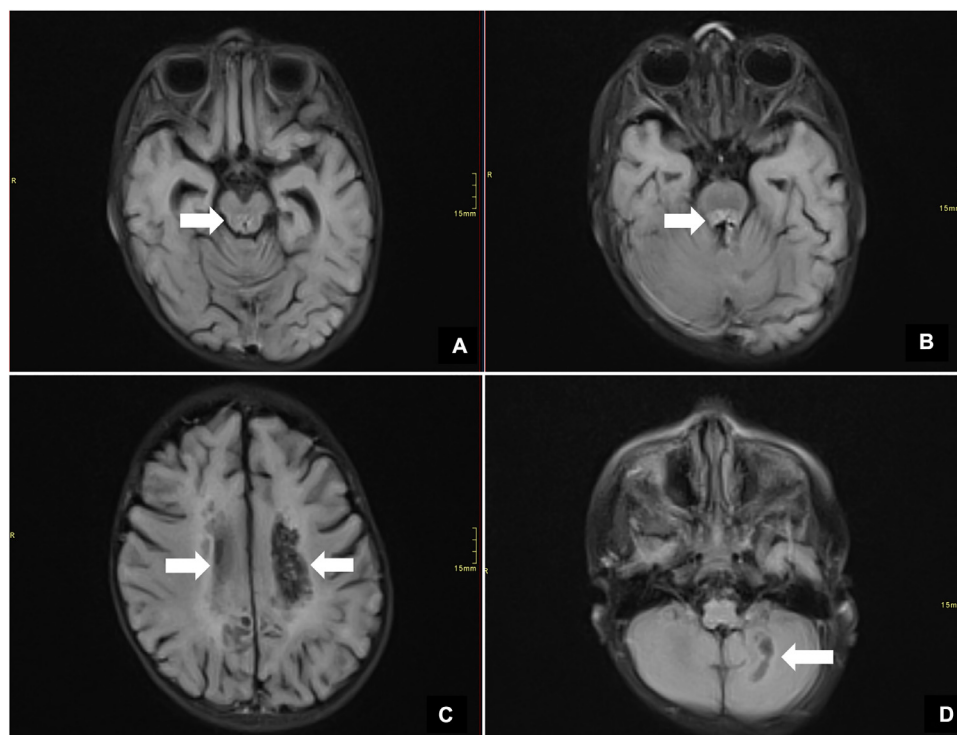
Axial FLAIR images of the brain. Focal areas of increased signal on FLAIR midbrain and pons (A) AND (B) with cystic areas adjacent (Arrows) which could represent cavitation. Bilateral cystic changes (arrows) were noted at the bilateral centrum semiovale and superior white matter (C) bilateral parasagittal areas and left cerebellum (D).
